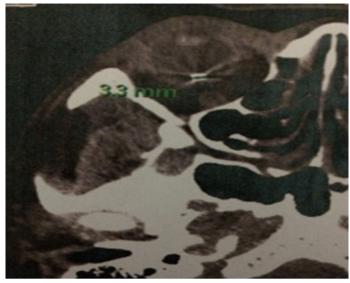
CT scan showing RIOFB
